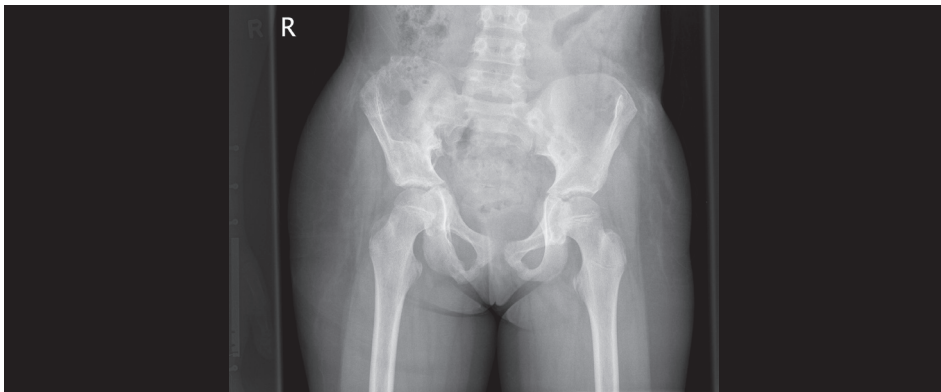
Pelvic radiograph one year after injury: uncomplicated fracture healing, removal of hardware, non-operatively treated anterior pelvic ring shows realignment. At follow-up after two years, the patient had a normal gait and was able to enjoy soccer and jazz ballet without much complaints.
